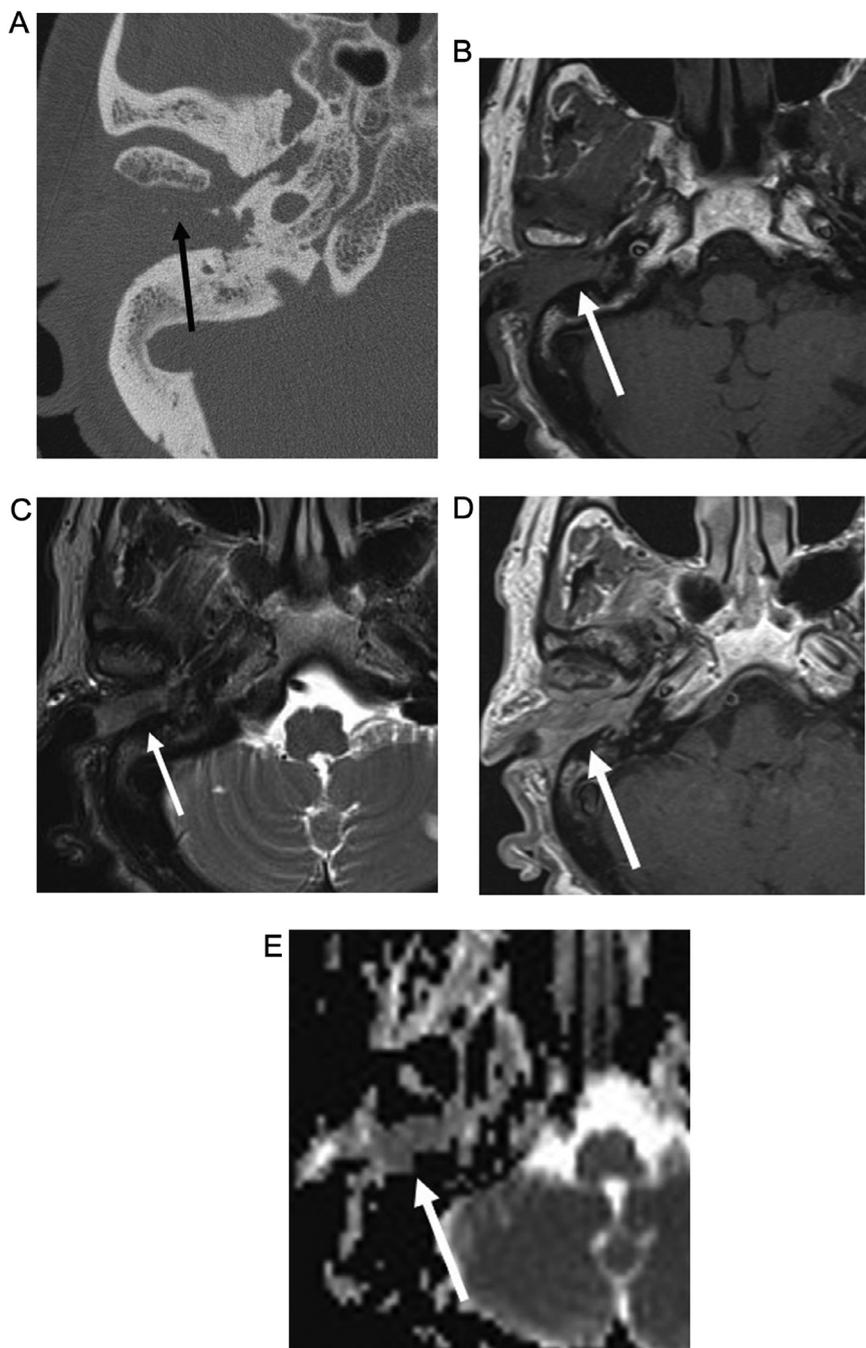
81f with EAC SCC. Axial CT image (A) shows erosion of the anterior wall of the EAC (arrow). Axial T1W image (B) shows the lesion to be hypointense (arrow) without surrounding streaking/inflammation in the surrounding soft tissues. Axial T2W image (C) shows the lesion to be hypointense (arrow) without cellulitis in the adjacent soft tissues. Axial postcontrast T1W image (D) shows enhancement of the lesion (arrow). ADC map image (E) shows homogeneous low signal within the lesion (arrow).
